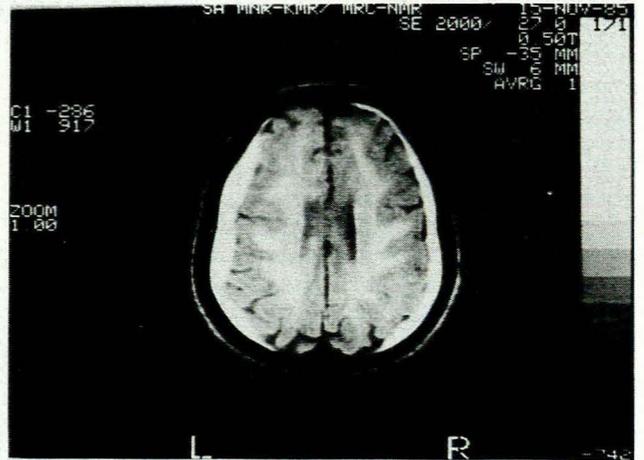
Comparable MRI image of the same patient (SE 2000/27) clearly showing bilateral subdural haematomas.
